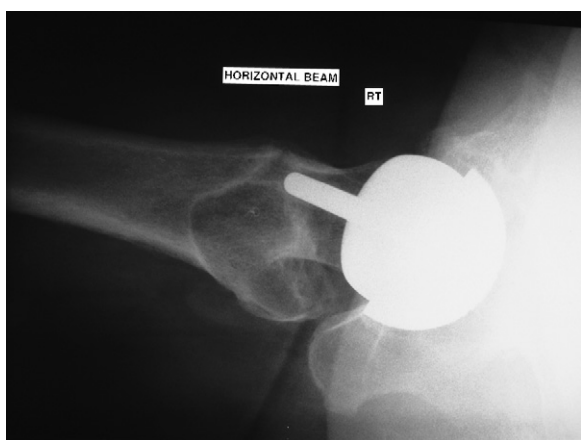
Patient 2 radiograph lateral right hip (United).
